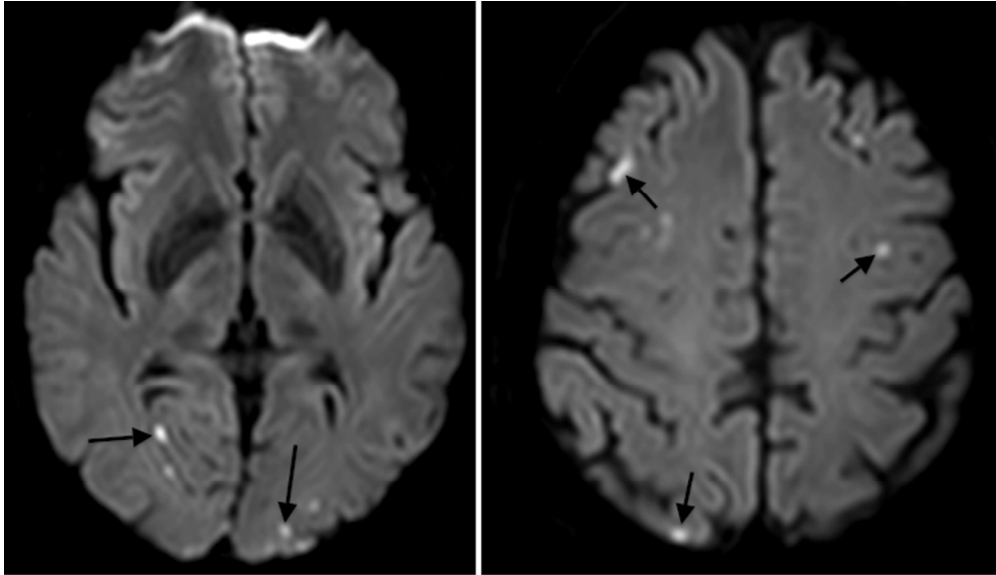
Axial diffusion-weighted magnetic resonance images acquired during the initial hospital admission, showing multiple infarcts bilaterally in the middle cerebral artery and posterior cerebral artery territories (black arrows).
